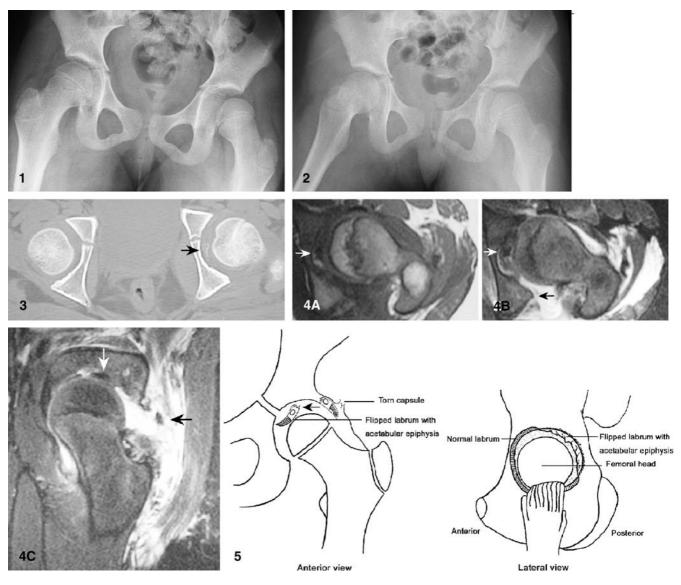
Anteroposterior radiograph of the left hip shows posterior dislocation
